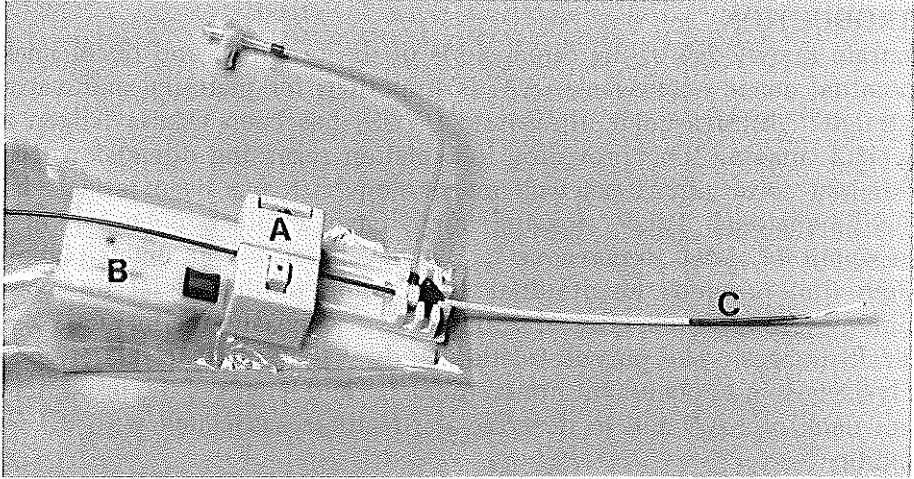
Displacement sensing device showing the disposable sterile sensing unit (A) and the registration unit (B) which is packed in a plastic, sterile bag. The ultrasound catheter (C) is advanced via the sensing unit and the sheath.
